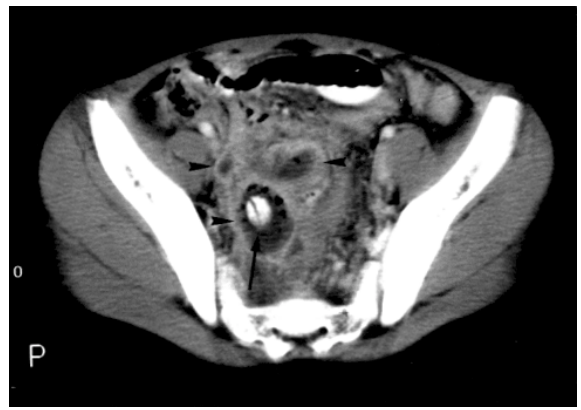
Appendiceal abscesses. CT image demonstrating inter-loop abscesses (arrowheads) in the pelvis due to a ruptured appendix. An appendicolith can be seen in one of the abscesses (a).
